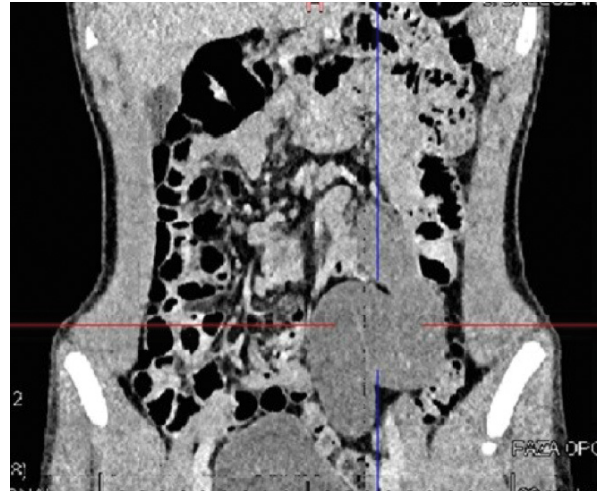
Preoperative abdominal CT with urography showing left ureteral dilatation (patient 2)
